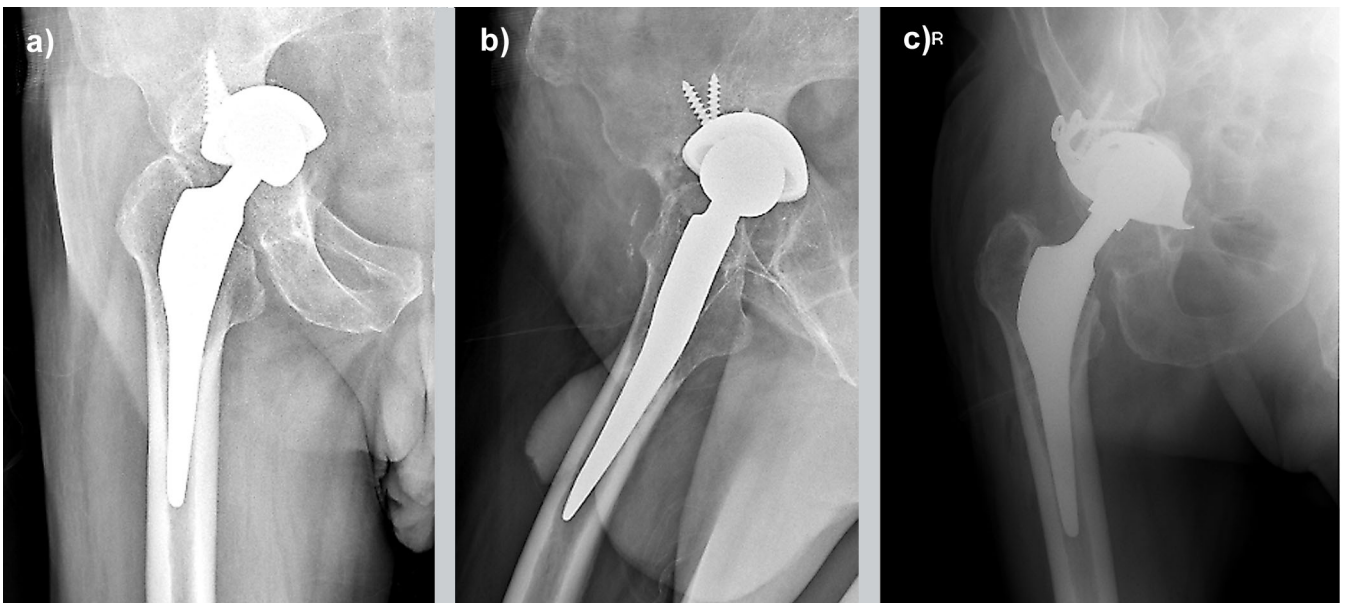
Radiographs of a 64-year-old man with Paprosky IIIB acetabular bone defect and pelvic discontinuity. a) Preoperative radiograph. b) Lateral view preoperative radiograph. c) Radiograph at 96 months after revision surgery show that the cage remained stable.
